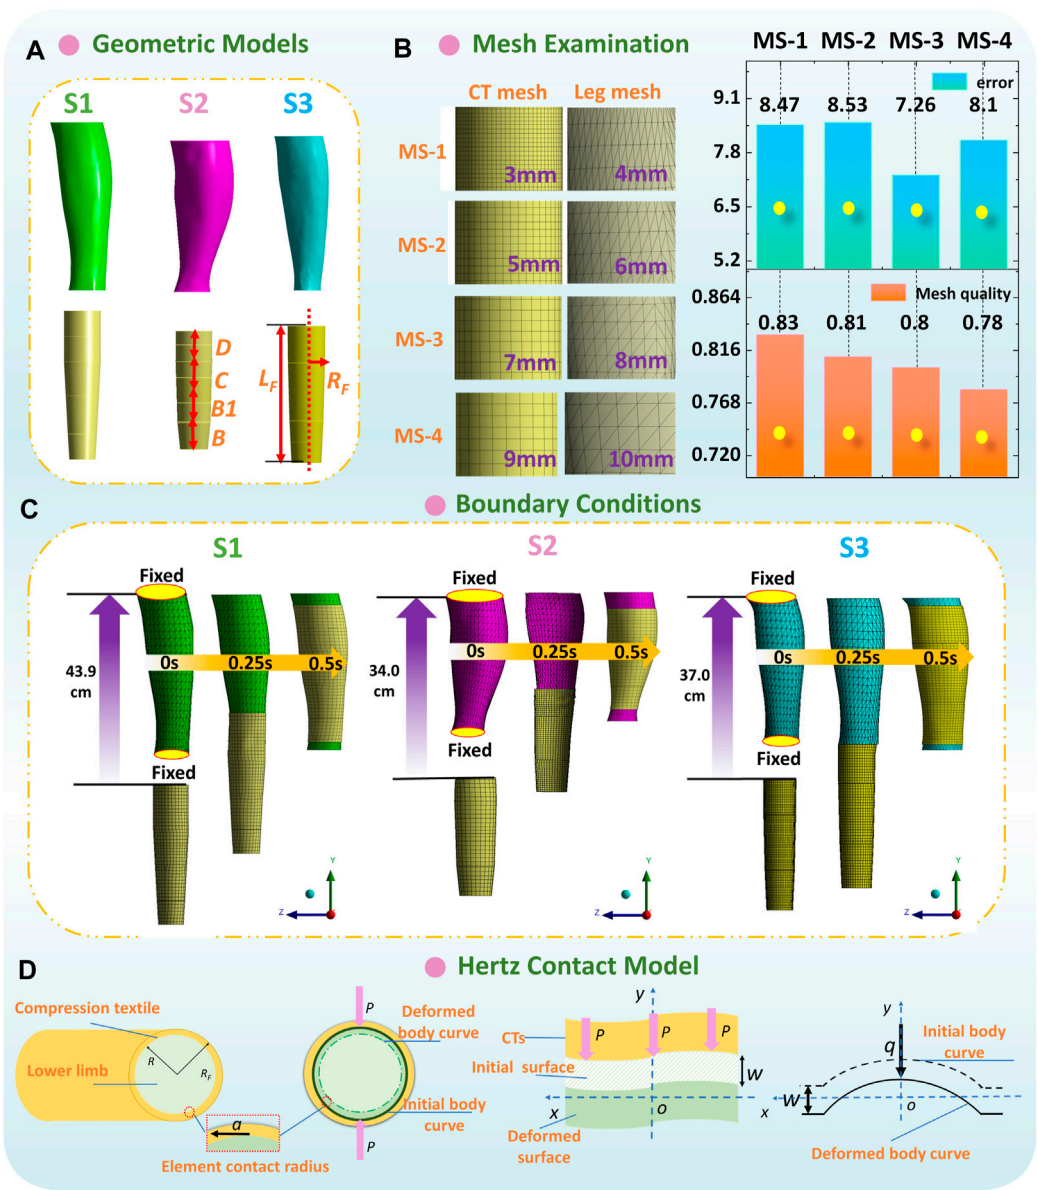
(A) Geometric models and (B) mesh sensitivity study of 3D FE homogenous modeling. (C) Boundary conditions and dynamic wearing process of each FE model. (D) Hertz contact model for the CT-leg system.
